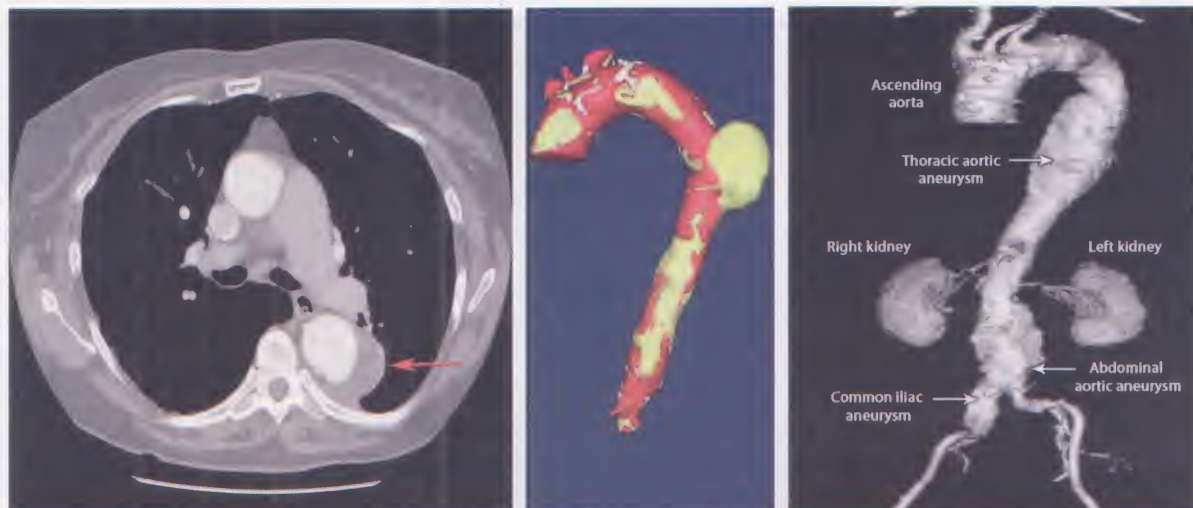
Contrast-enhanced CT scan of the chest (left image) showing aneurysm of the descending thoracic aorta (arrow). Two different three-dimensional reconstructions of CT scans of the chest and abdomen (the middle and right images) showing aortic aneurysms in different patients
